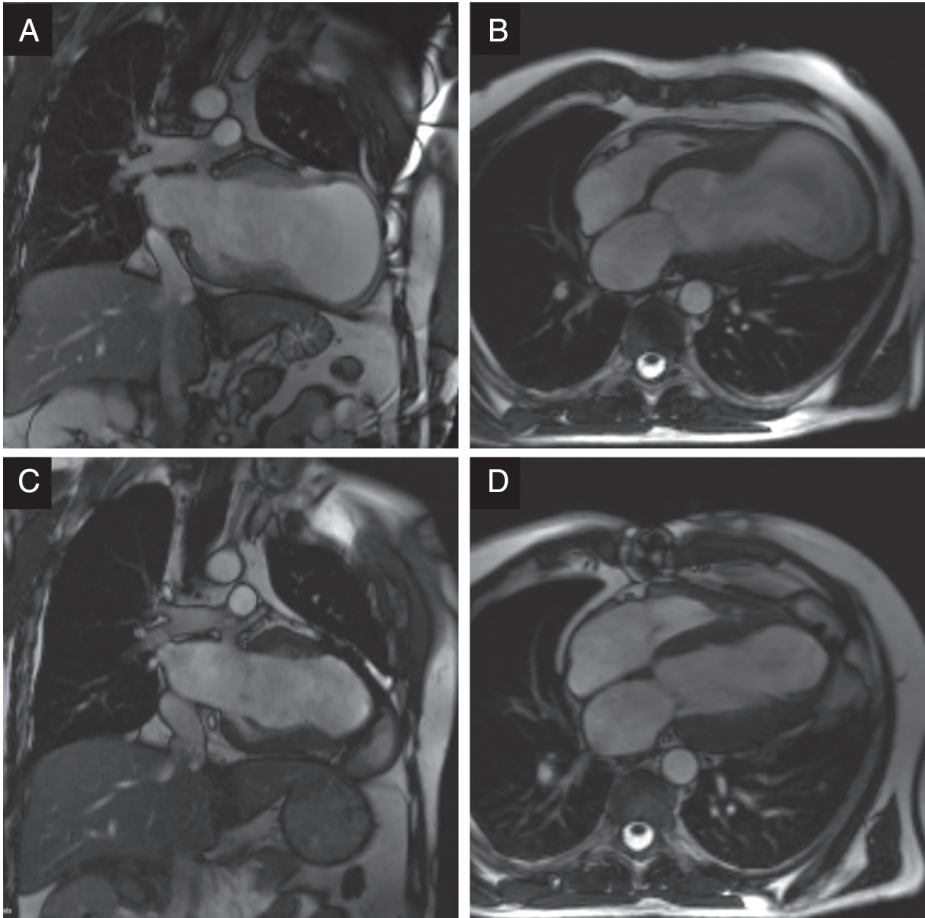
Magnetic resonance images of the heart pre- and post-surgery. On-site images taken before surgery show a large apical aneurysm post-myocardial infarction with increased ventricular volume and thinned wall [two-chamber orientation (A); four-chamber orientation (B)]. Images taken 6 months after surgery show significant volume reduction and reshaping of the left ventricle [two-chamber orientation (C); four-chamber orientation (D)].
